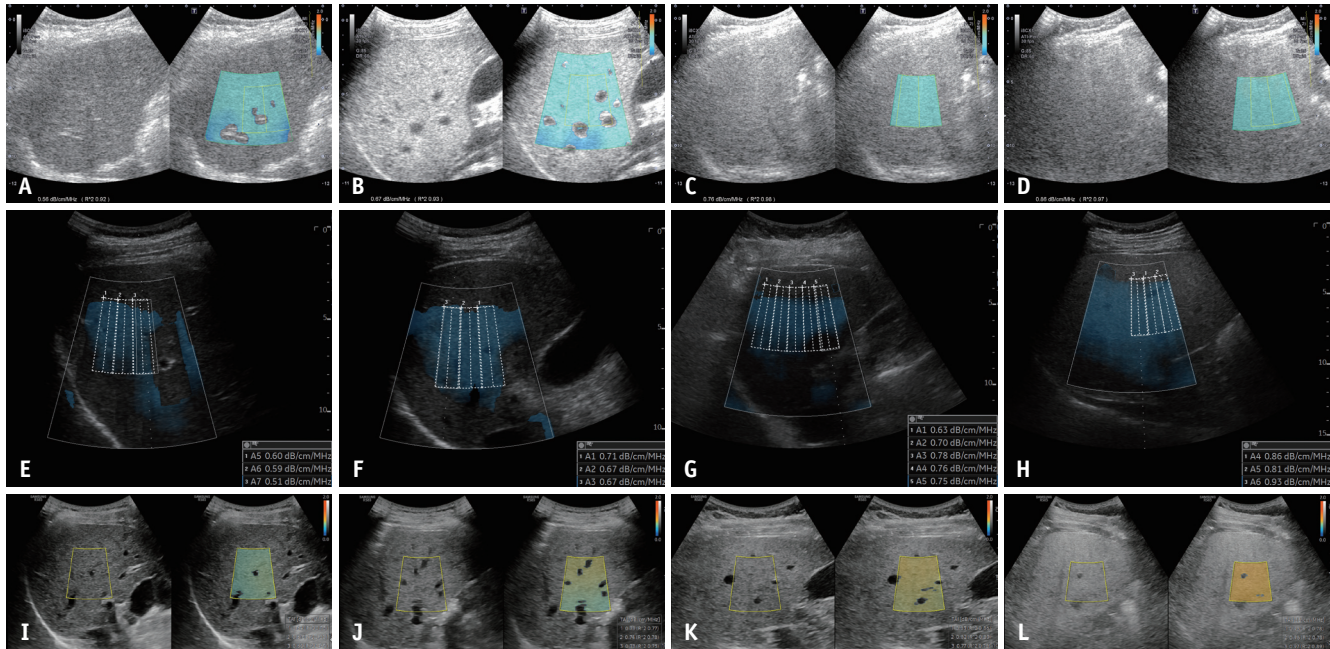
Various commercialized techniques for B-mode ultrasound-guided attenuation imaging.
